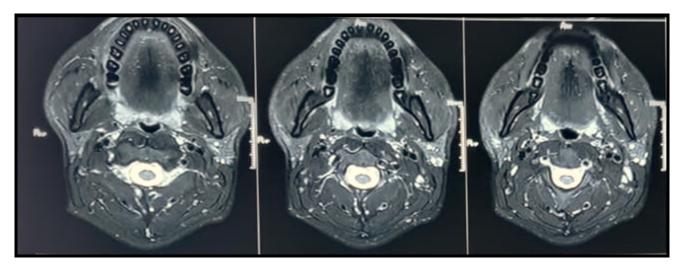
MRI scan axial cuts showing heterogenously enhancing soft tissue lesion in the superficial lobe of right parotid tissue.
